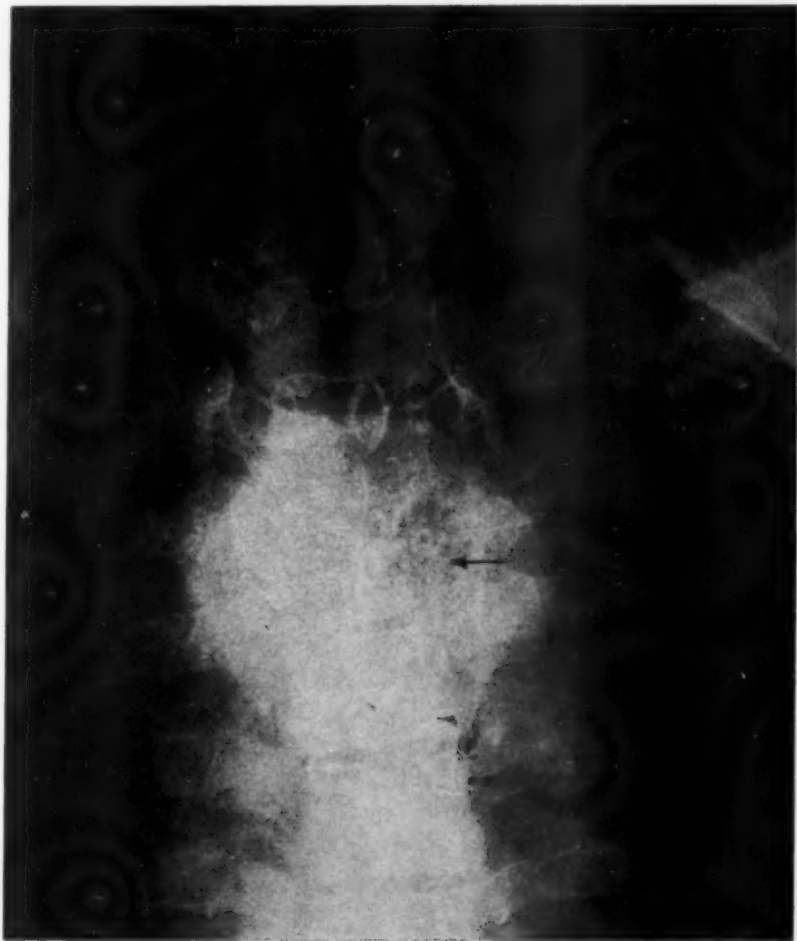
Roentgenogram showing destruction of right pedicle of T₄ with soft tissue mass.
